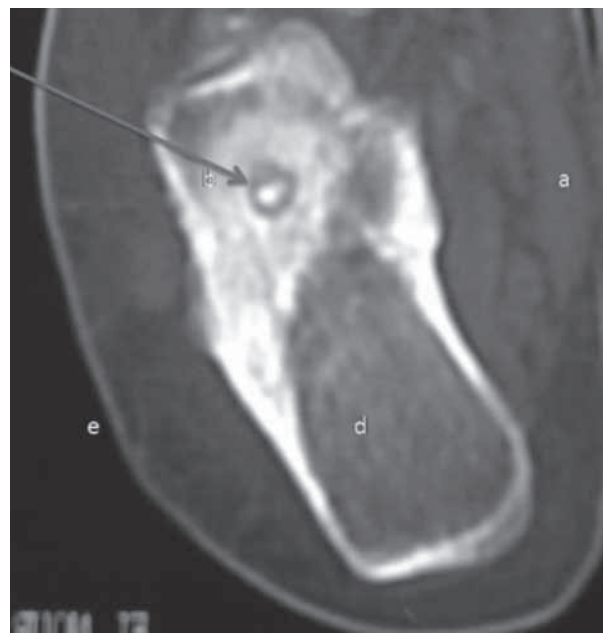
Same patient as in fig. 2. CT-scan : axial section of the right calcaneus. Osteoid osteoma, but the reactive sclerosis is wide-spread.
